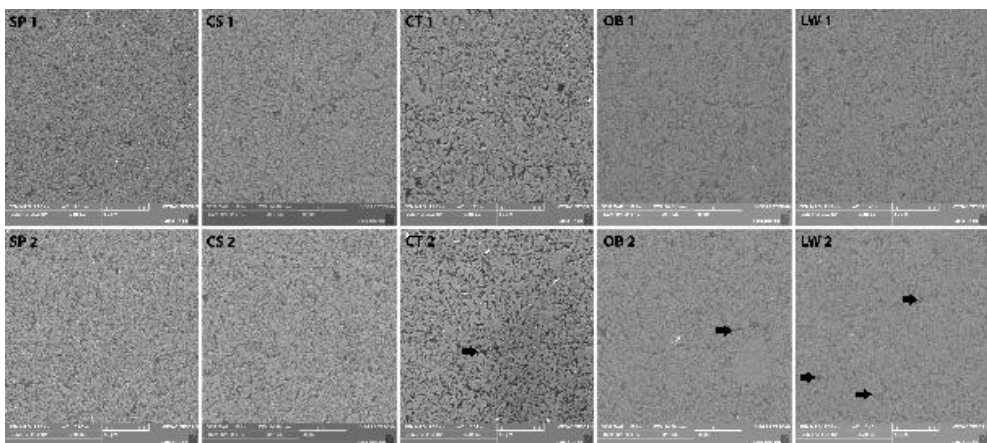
Representative SEM images of the Vita Enamic material, with a magnification of $\times 1000$, from before (1) and after brushing (2) with sensitivity (SP and CS), regular (CT), and whitening (OB and LW) toothpastes. The black arrows point to the cracks or scratches caused by brushing.
